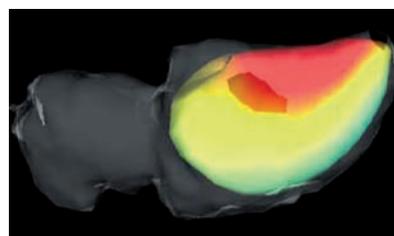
Magnetic resonance imaging (MRI) view of the left ventricular endocardial surface showing the mapped electrical activity during early systole. The electrical data were measured using the EnSite system and fused with the MRI data using hybrid X-ray/MRI registration technology.
